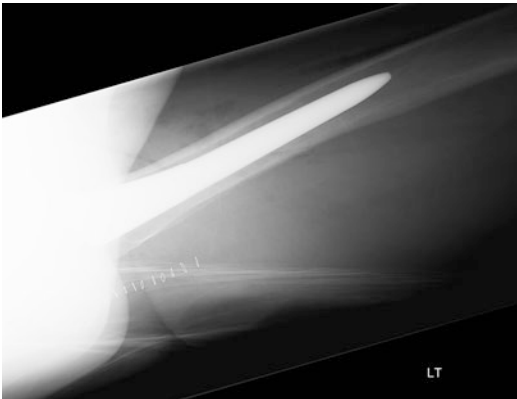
Lateral postoperative X-ray image of the *left hip* following primary total hip arthroplasty. The image showed suspicion of an undisplaced proximal femur fracture
